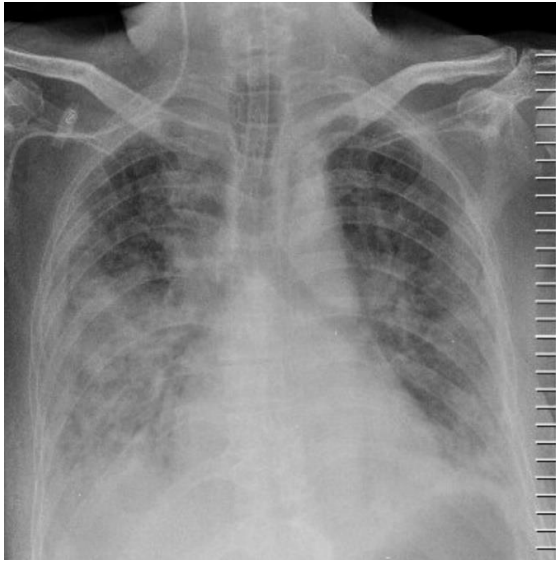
Chest X-Ray (30th Day)
